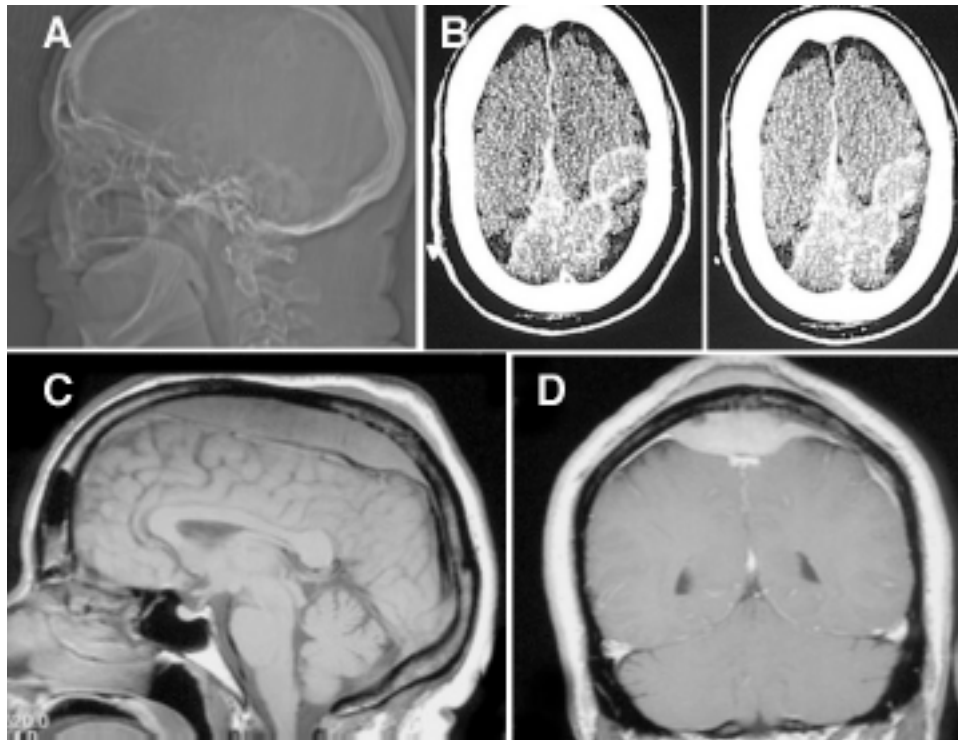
Sagittal scout view (A) revealing no evidence of lytic or blastic lesions in the cranial vault. Head CT scans (B) obtained without addition of contrast material, demonstrating an extraaxial bilateral frontoparietal lesion involving the cerebral falx and meninges. Sagittal and coronal T1-weighted MR images obtained without (C) and with (D) gadolinium contrast, demonstrating a contrast-enhanced (in D), transcalvarial mass that permeates the diploic space and occupies the subgaleal space.
